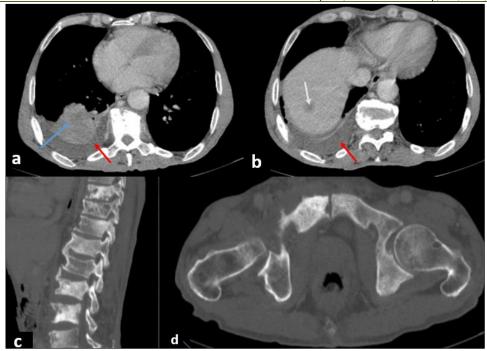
CT imaging reveals a spiculated mass in the right lower lobe, consistent with a primary lung lesion (blue arrow). Findings at characteristic sites of metastatic involvement include a moderate right pleural effusion (red arrow), numerous mixed lytic and sclerotic bone metastases, and multiple well-defined hypodense liver metastases (white arrow)
